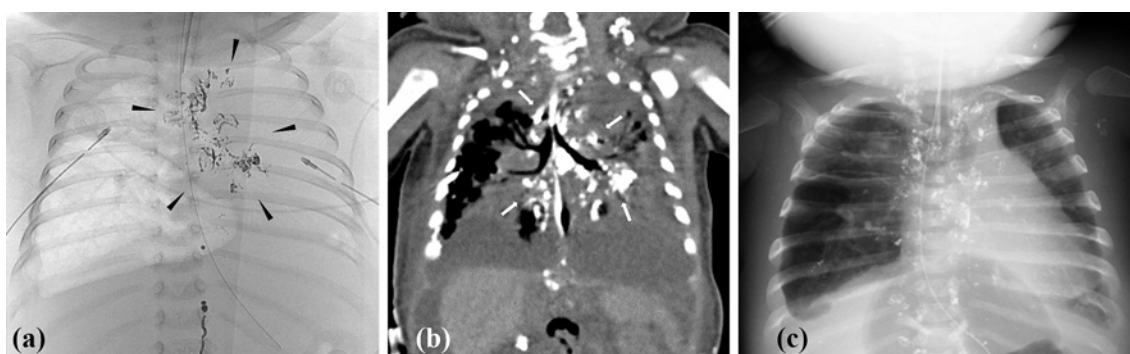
(a) A fluoroscopic image captured during lymphangiography, showing backflow of ionized oil into the left peribronchovascular lymphatics (black arrowheads). The air content of the left lung was reduced. (b) A CT image captured after the lymphangiographic procedure, showing ionized oil deposition in the bilateral peribronchovascular lymphatics (white arrows). (c) A chest radiograph taken 1 month after the lymphangiography procedure, showing the resolution of the pleural effusion. Chest drainage tubes had been removed before this stage. Ionized oil deposition in the mediastinal and left axillary lymph nodes was also observed.
